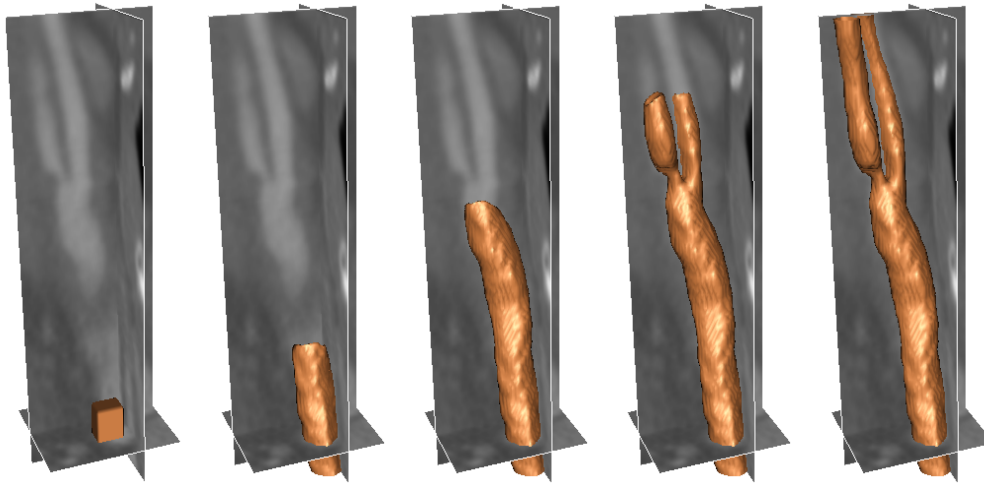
Segmentation of carotid artery from CT image dataset 1 (61x71x125) using GPF deformable model (CPU-time, 276s).
